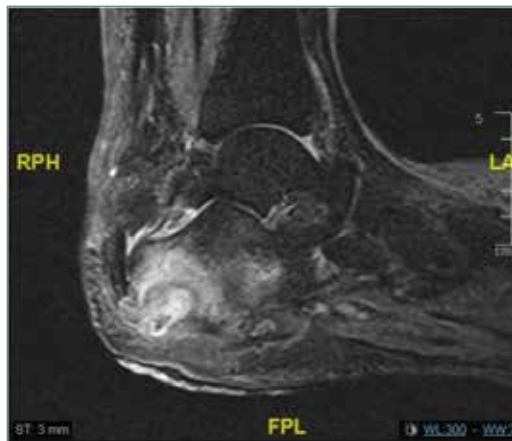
MRI of calcaneal osteomyelitis – STIR sequence, sagittal section.
